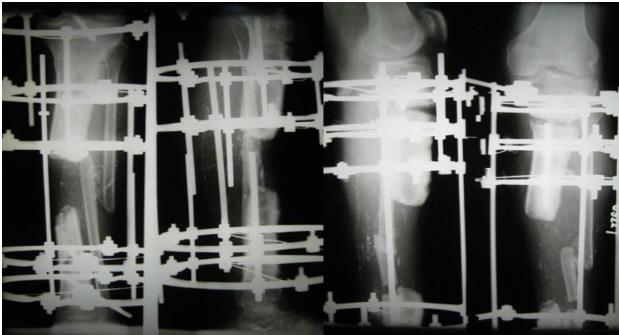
Immediate postoperative X-ray showing Ilizarov fixator application in a case of infected gap non-union of Tibia with proximal metaphyseal corticotomy.
